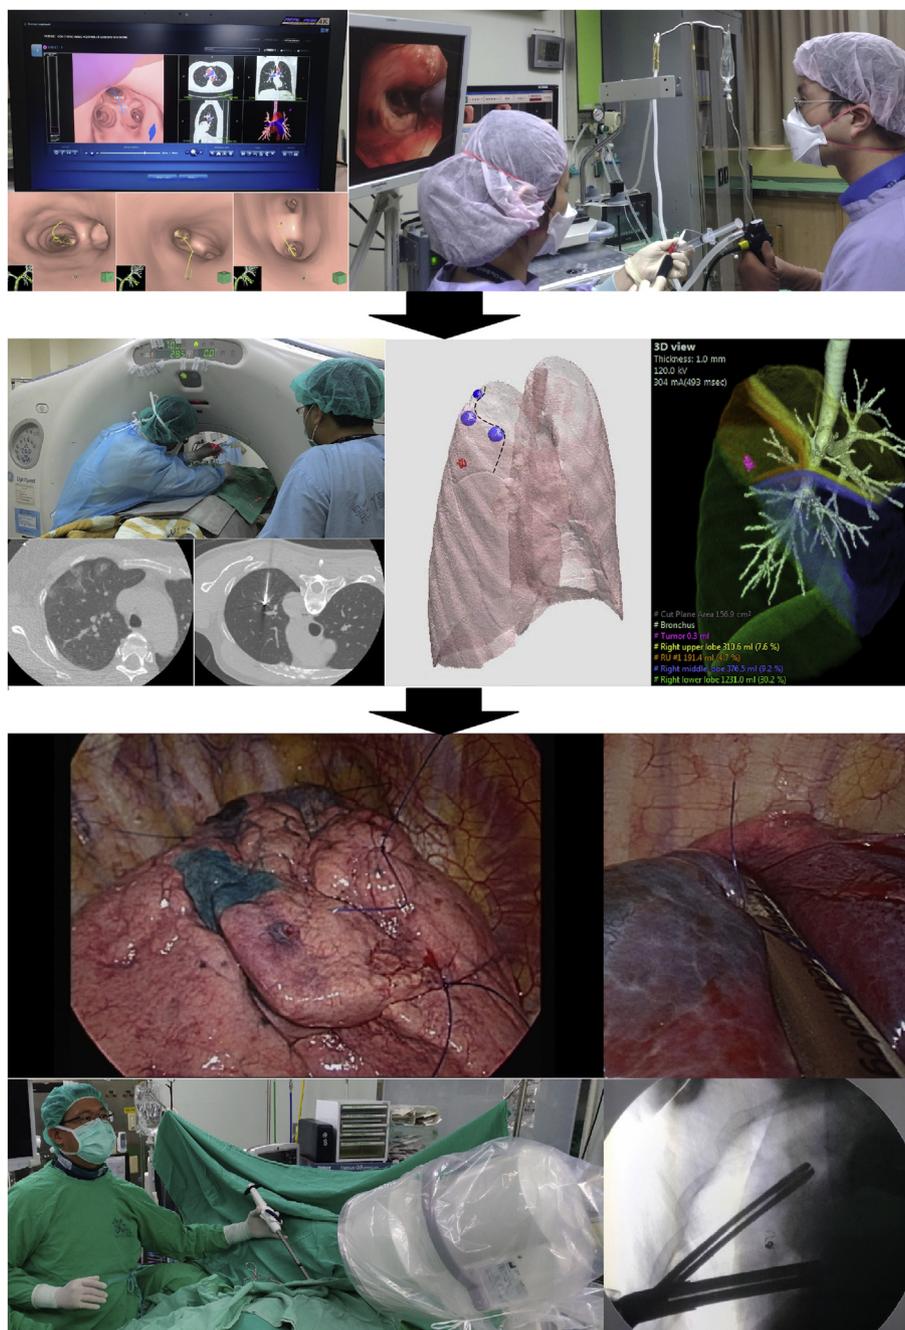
Steps in combination of VAL-MAP, CT-guided localization, and image-guided surgery.
